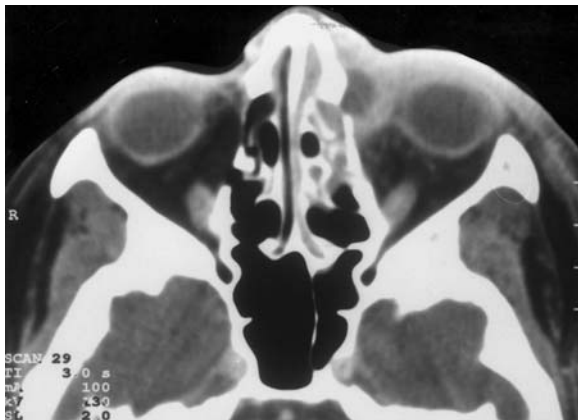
A 55-year-old woman with extra-axial proptosis and slowly progressing ptosis of the right eye with concomitant extra-axial caudal dislocation of the globe. Diagnosis: chronic fibromatous dacryoadenitis. a Portrait of the patient with secondary ptosis of the right eye. Contrast-enhanced CT: b Axial view showing an irregular configuration of the enlarged right lacrimal gland, enveloping the globe at the upper circumference. c Coronal view demonstrating the lobulated surface of the apparently smooth lesion, but no depression of the globe
